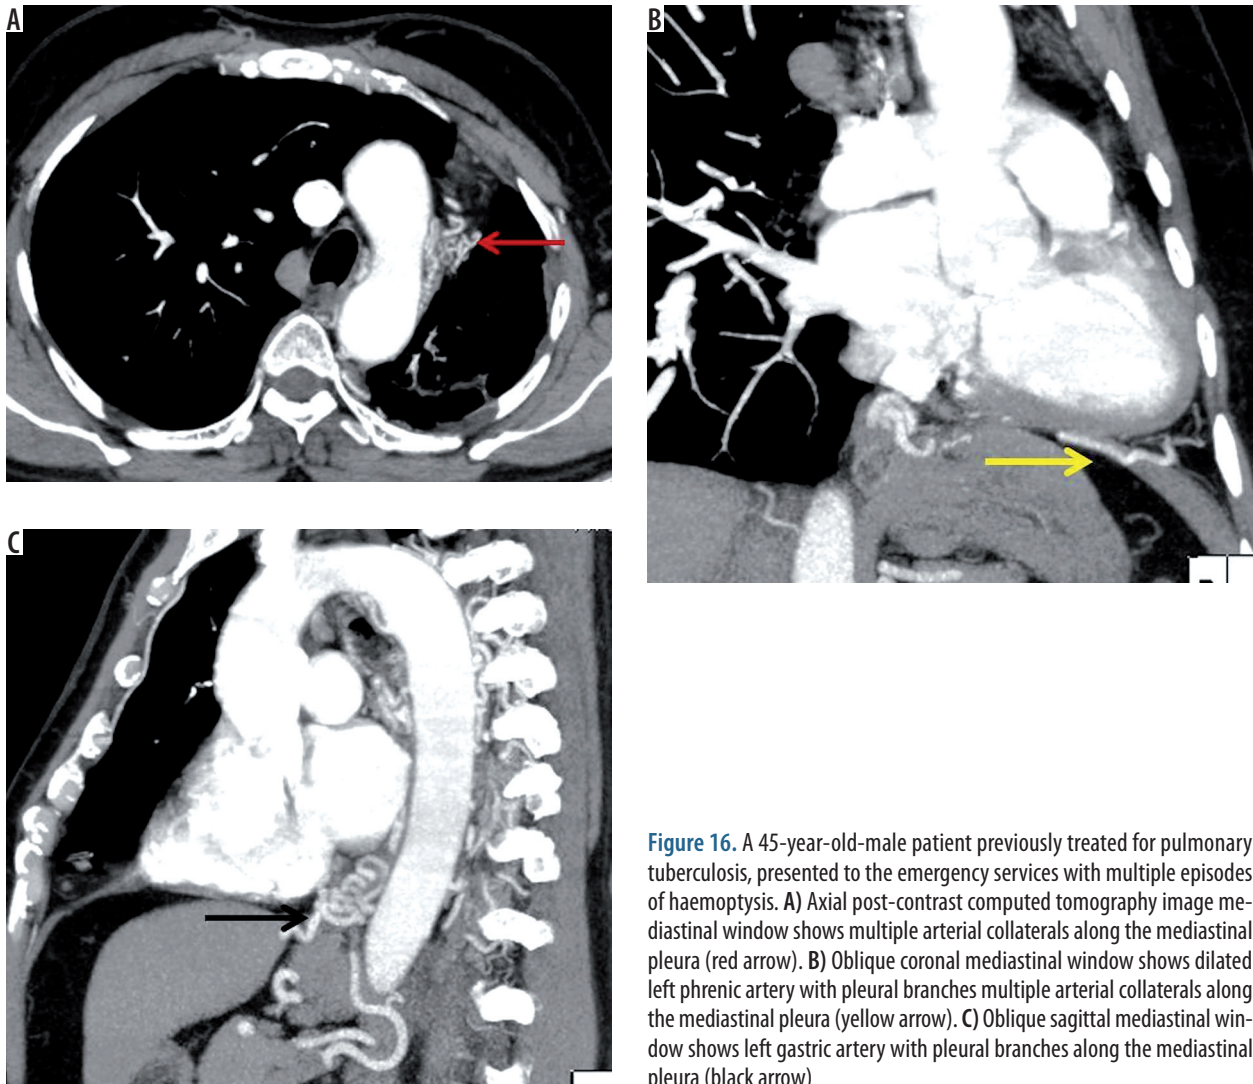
A 45-year-old-male patient previously treated for pulmonary tuberculosis, presented to the emergency services with multiple episodes of haemoptysis. A) Axial post-contrast computed tomography image mediastinal window shows multiple arterial collaterals along the mediastinal pleura (red arrow). B) Oblique coronal mediastinal window shows dilated left phrenic artery with pleural branches multiple arterial collaterals along the mediastinal pleura (yellow arrow). C) Oblique sagittal mediastinal window shows left gastric artery with pleural branches along the mediastinal pleura (black arrow)
